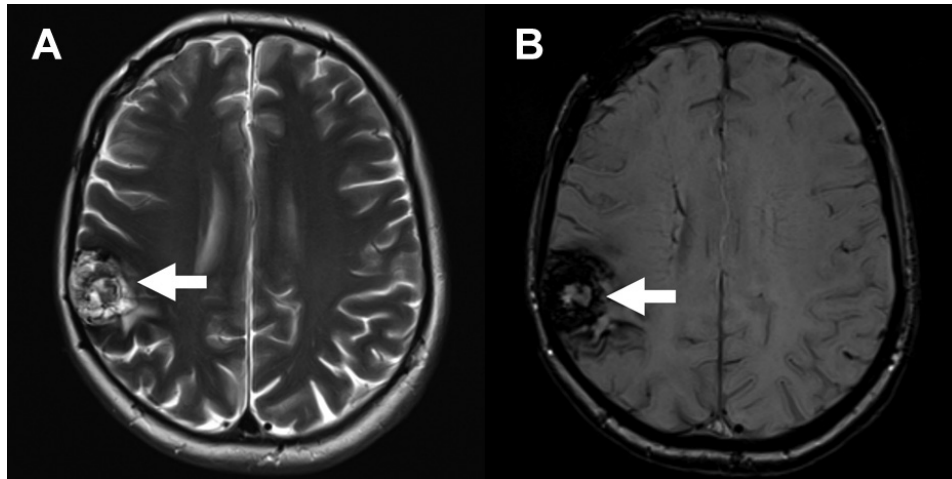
Example of a cavernous malformation MRI of a patient with a symptomatic (headache) cavernous malformation in the right parietal lobe. The cavernous malformation shows heterogeneous signal in T2-weighted images (A) with a popcorn-like appearance. Susceptibility-weighted imaging (B) shows the hypointense rim at the periphery of the malformation, which is typical for this disease. MRI: magnetic resonance imaging
